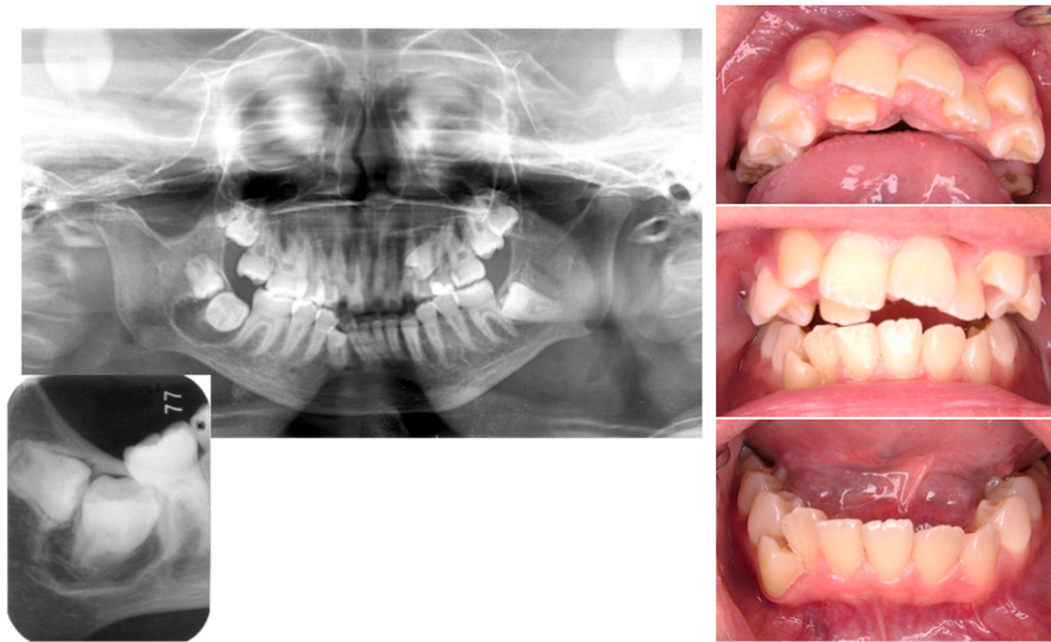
An intraoral photograph and X-ray at the first visit out clinic (14 years and 3 months). It is indicated lower left first molar dentin caries, upper left second primary molar prolonged retention, upper left second premolar malposition and impaction and lower right third molar and second molar follicular dental cyst.
